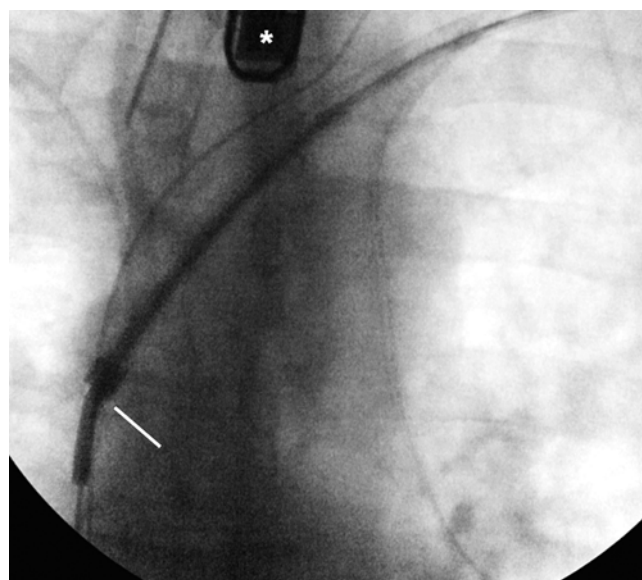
Fluoroscopy image of the laser sheath at the superior vena cava. Lead dissection at the innominate vein-SVC-RA junction is the most dangerous area for a venous tear. This case is further complicated by the presence of a non-back-filled superior vena cava lead coil (dual coil ICD lead). In the current technological era of effective intracardiac defibrillation, dual coil lead implant should be rarely required. Note the bevel orientation of the laser sheath (approximated by the *white line*). Adequate traction on the lead allows a completely coaxial orientation of the sheath during lasing. This area was safely cleared with a 16 Fr sheath. Transesophageal echocardiogram probe is also seen (*). It is withdrawn to the superior esophagus to allow optimal fluoroscopic visualization of the leads
